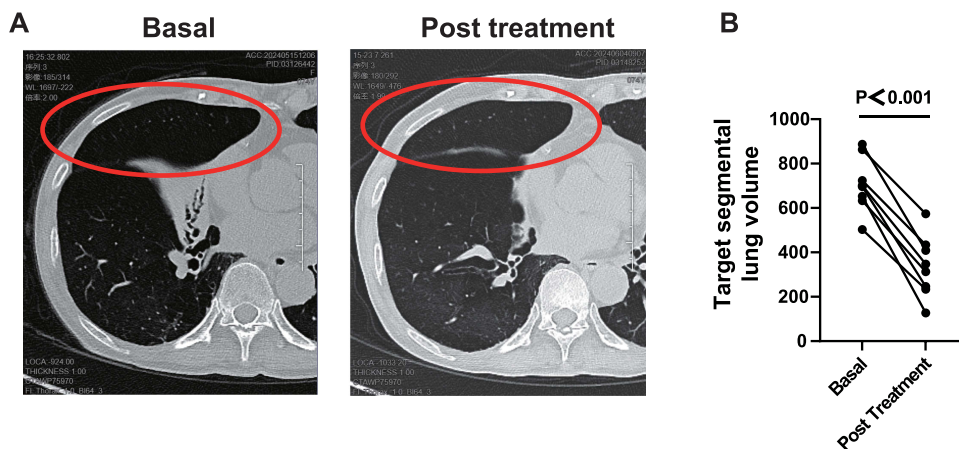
CT imaging and target segmental lung volume changes following Bronchoscopic Thermal Vapor Ablation (BTVA) in COPD patients. (A) Representative axial CT images showing the target segment before (left) and after (right) BTVA treatment. The target segment is highlighted by the red circle. (B) Change in target segmental lung volume between baseline and post-treatment. Data are presented as individual patient changes, and statistical comparison was performed using paired t-test.
